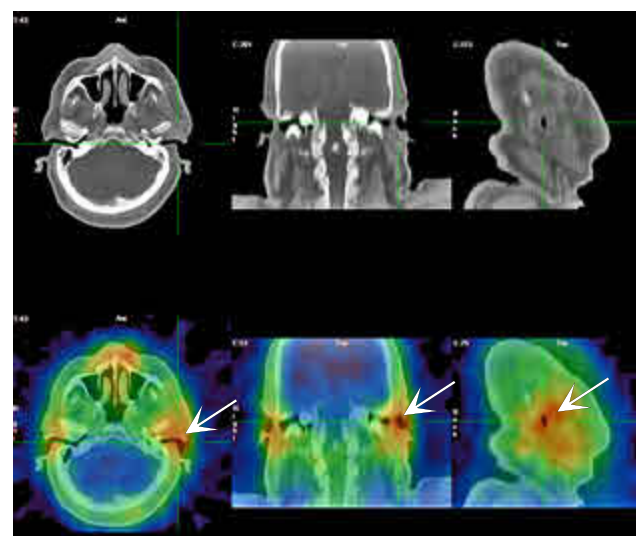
CT (top row) and fused SPECT-CT MDP bone scan images showing discrete increased uptake in the left temporomandibular joint (arrows)
